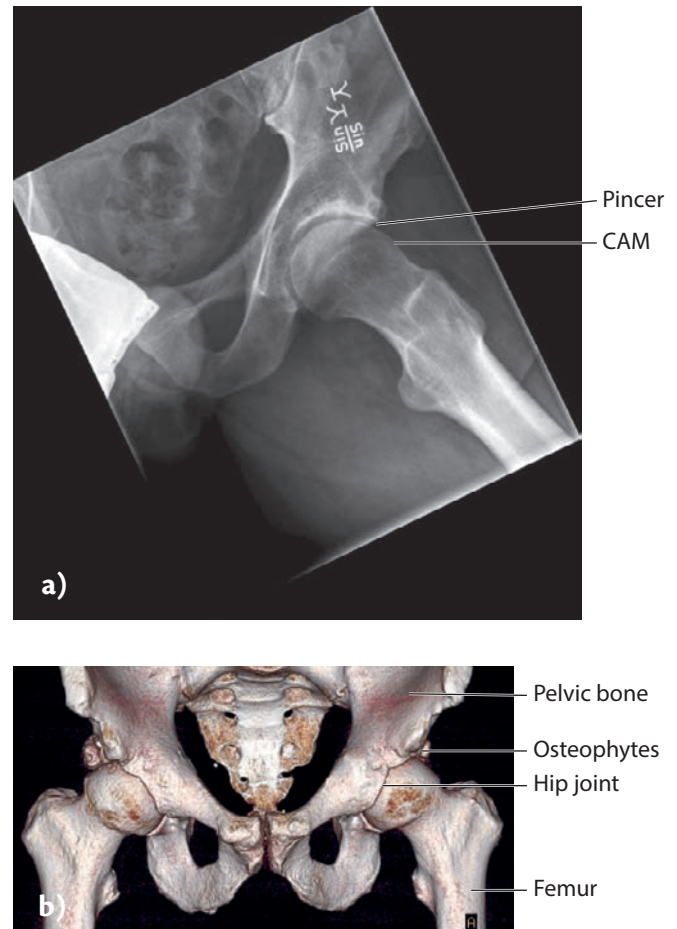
Femoroacetabular impingement (FAI) in the hip joint. a) X-rays in the frog position show changes corresponding to pincer at the edge of the acetabulum and cam on the femoral neck; b) CT scan reconstruction shows pronounced bone formation (osteophytes) on top of the acetabulum causing FAI.
